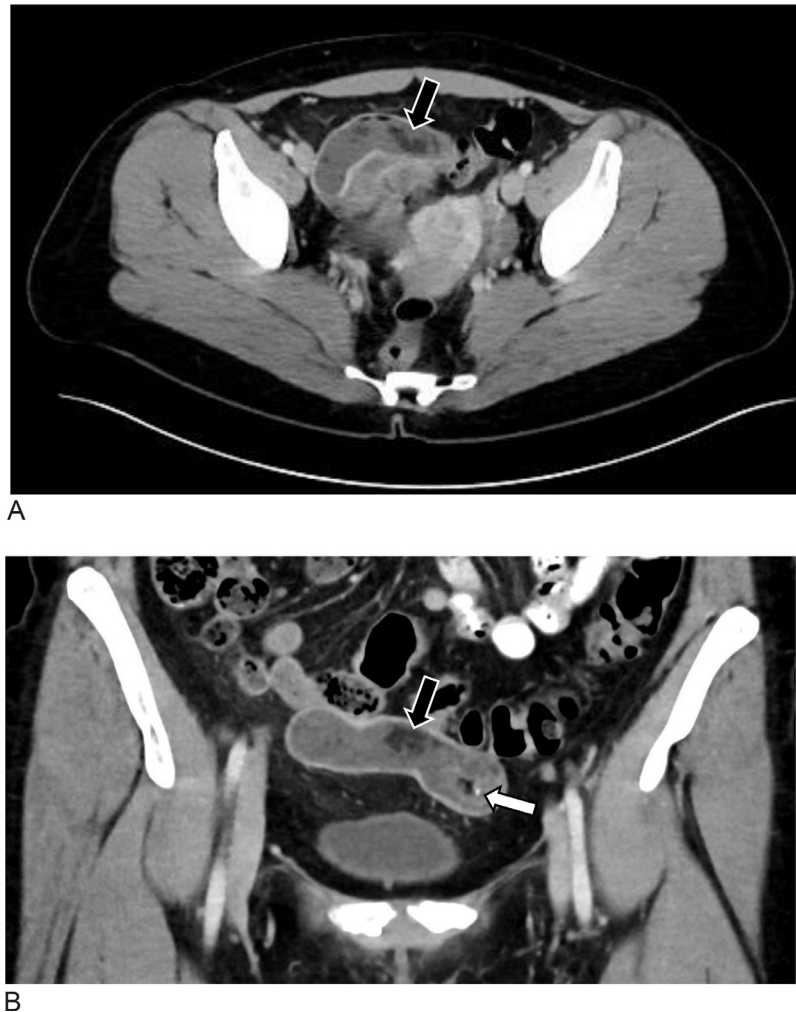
Transverse (A) and coronal (B) CT images show a dilated fallopian tube containing macroscopic fat (black arrows) and a punctate calcification (white arrow in Fig. 1B).
